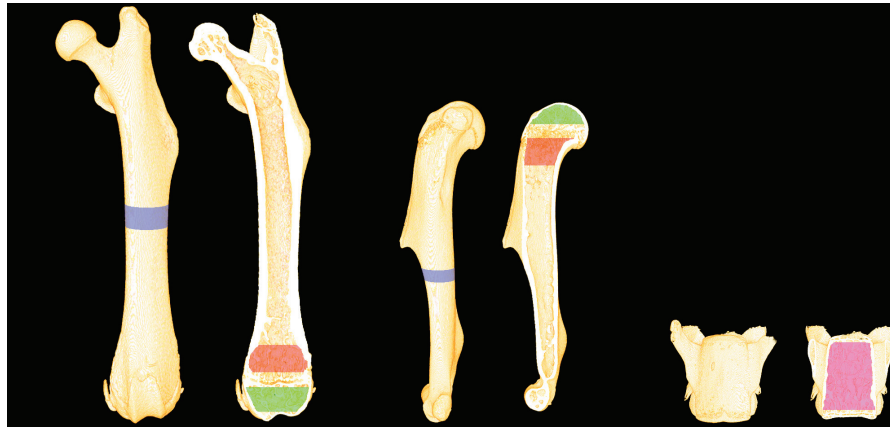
Volumes of interest (VOI) analyzed by μ CT. The size of the femur, humerus, and vertebra are proportional to each other. The blue area represents the VOI at the diaphyses, the red area represents the VOI at the metaphyses, the green area represents the VOI at the epiphyses, and the pink area represents the VOI at the corpus vertebra.
